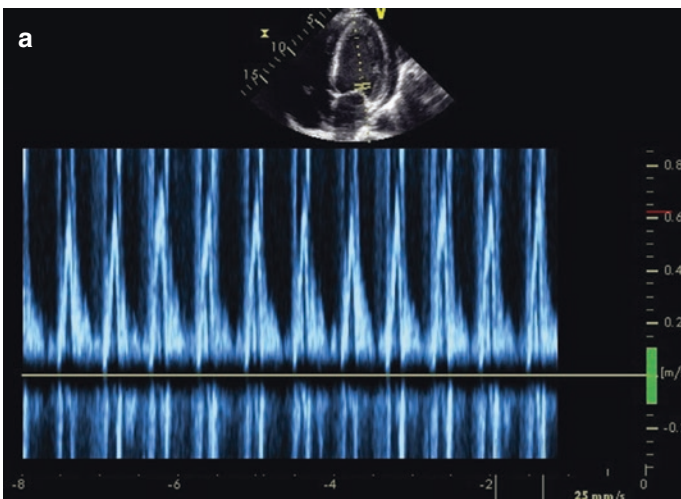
Flow velocity variation across the mitral valve. Mitral inflow velocities can be recorded by pulse wave or continuous wave spectral Doppler. Doppler recording requires a proper cursor positioning, adequate scale and appropriate sweep speed. Normally and in patients with asymptomatic effusions, there is insignificant variation in flow velocities across the mitral valve (around 5%) related to inspiration: flow
